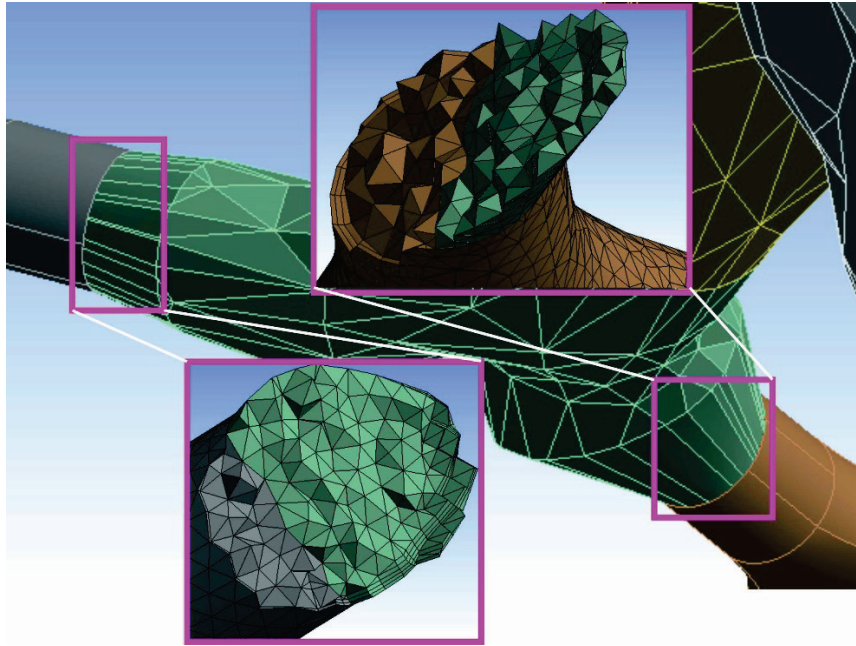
Lung model up to the 16th generation, grey color mesh is the part obtained from CT, green color bets to the adaptation solid and brown color is the parametric part. It can be observed the mesh, with tetrahedral cells and five inflation layers over the walls.
